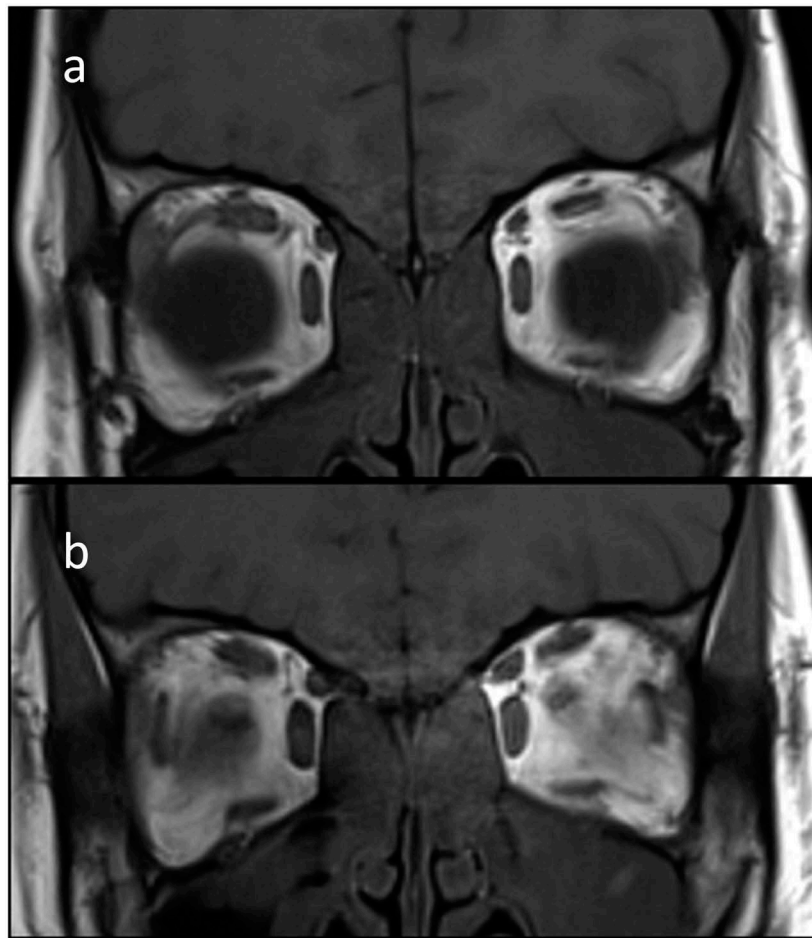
T1-weighted magnetic resonance imaging of the (A) anterior and (B) posterior orbits demonstrating a smaller left superior rectus muscle.
